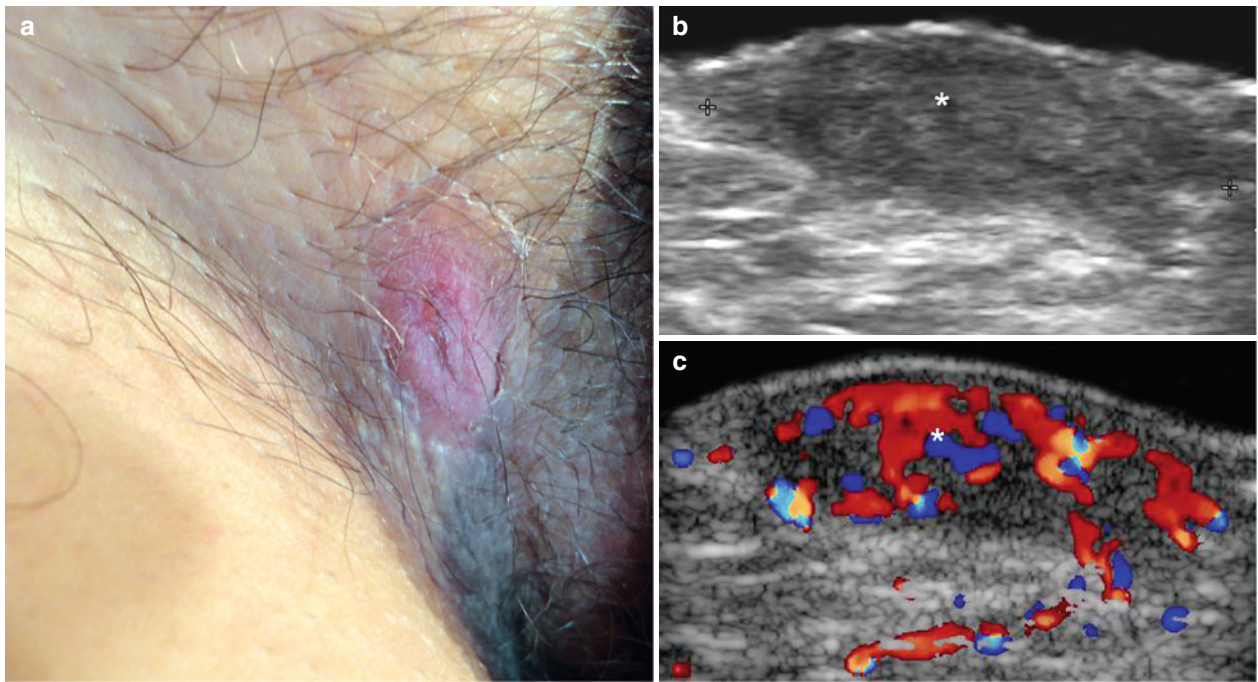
(a–c) Hidradenitis suppurativa. (a) Clinical image shows erythematous bump in the right groin (Hurley I). (b) Gray scale ultrasound image (transverse view) demonstrates hypoechoic fluid collection with prominent echoes (debris and inflammatory/granulomatous tissue) (*, between markers) in the dermis and upper subcutaneous tissue. (c) Color Doppler ultrasound image (transverse view) shows increased blood flow in the collection
